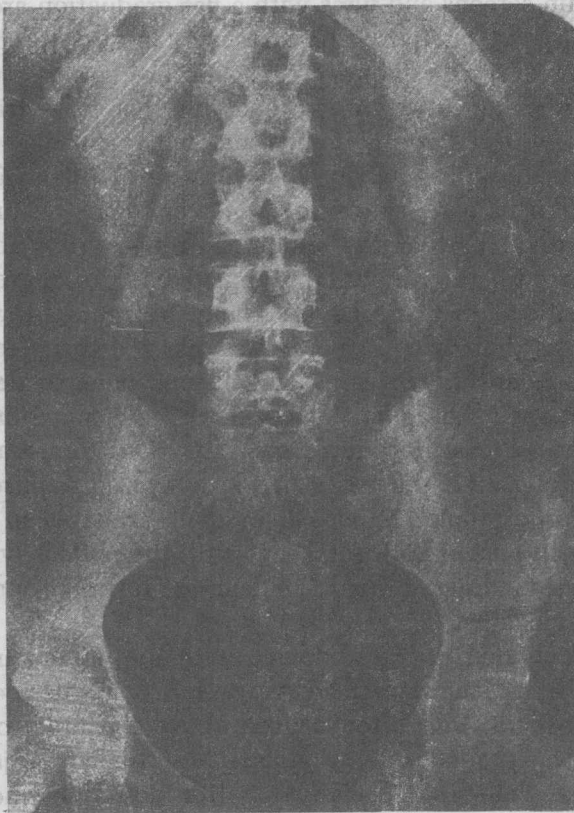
Plain film of the abdomen. Intestines nearly devoid of gas. Psoas margin sharply defined.
